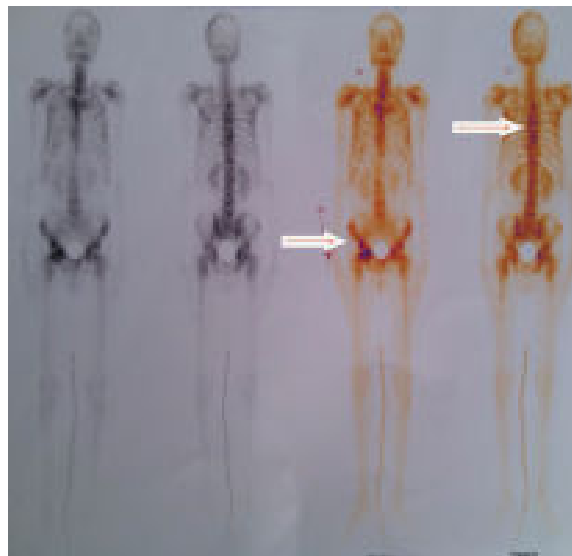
Bone scintigraphy showed increased tracer uptake in T5, T6, T7, T9 vertebra and right ischium (arrow) including right hip joint – suggestive of infiltrative bony lesion.
